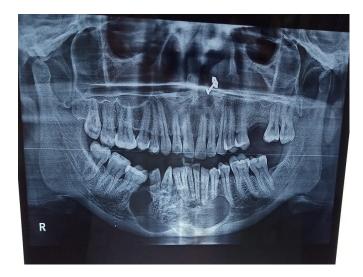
orthopantomogram shows multilocular radiolucencies in the right front side of jaw.
